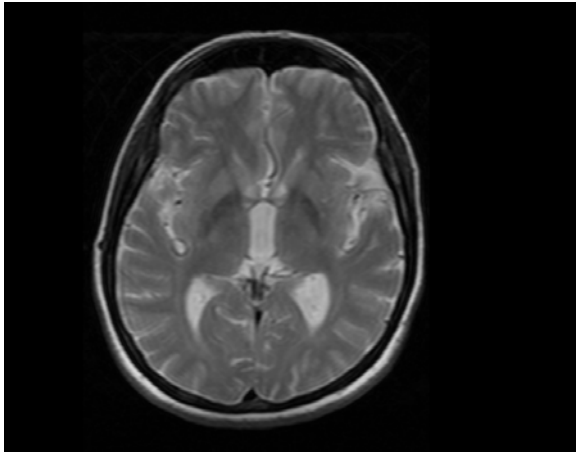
T2-weighted cranial MR image showed hypointense areas in both globus pallidus.
